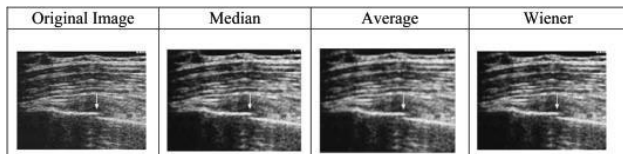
Rib fracture ultrasound image using Median, Average and Wiener.
